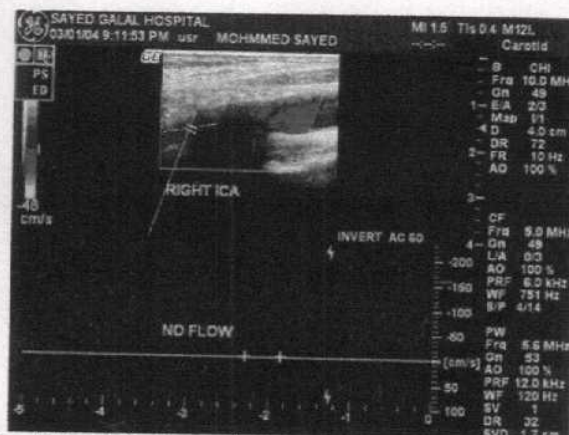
c): No Doppler signal waveform of Rt ICA.
